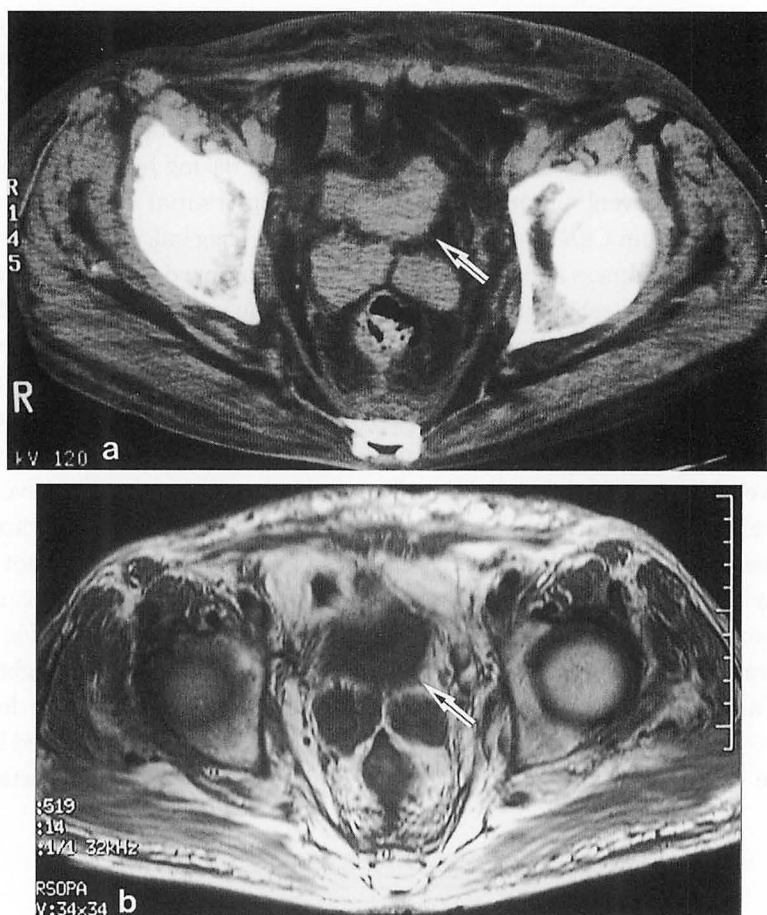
a : Computed tomograph of the pelvic region taken on March 21, 2001. An isointensity lesion of the bladder wall protruding slightly toward the left back (←) is visible.
